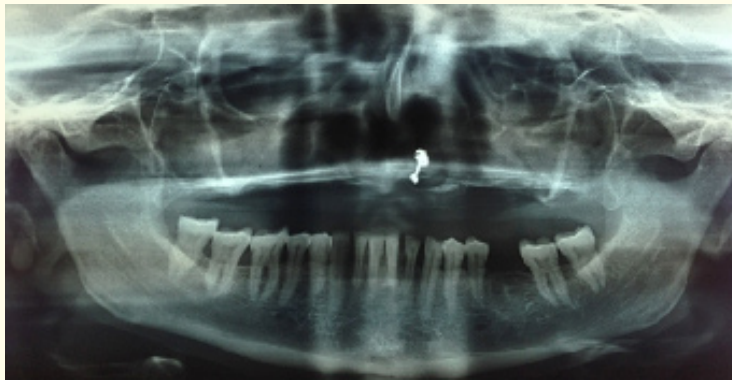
Orthopantomograph revealing moth eaten appearance of the maxillary alveolar bone.
